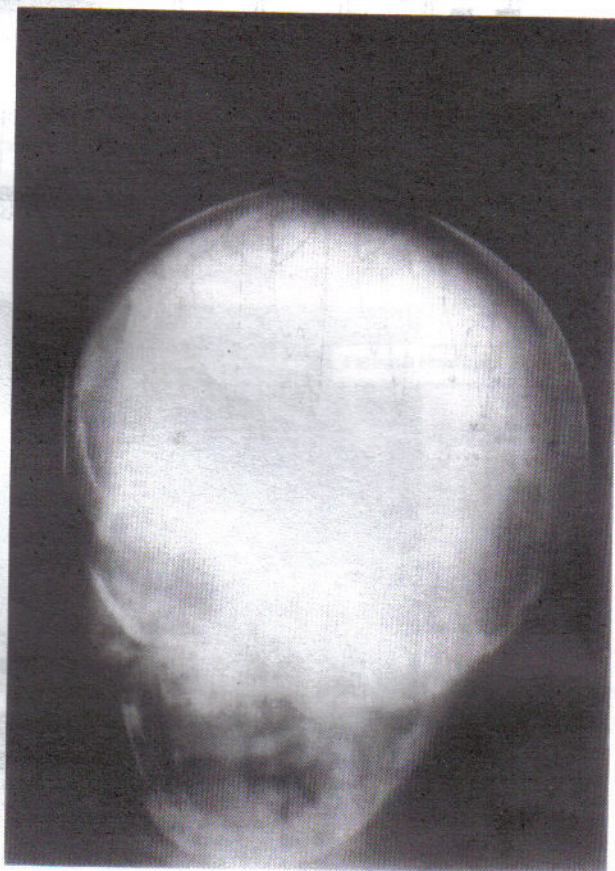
Xray of the skull
